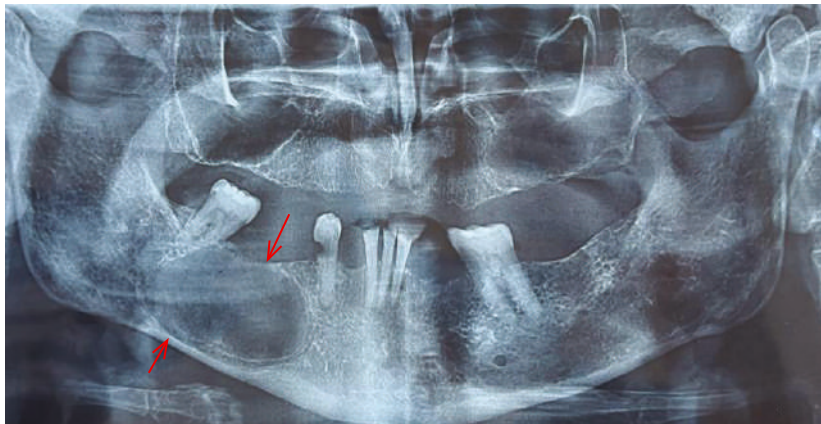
Orthopantomogram (OPG) showing a well-defined unilocular radiolucent lesion involving the right posterior mandibular region extending from 45 to 47
